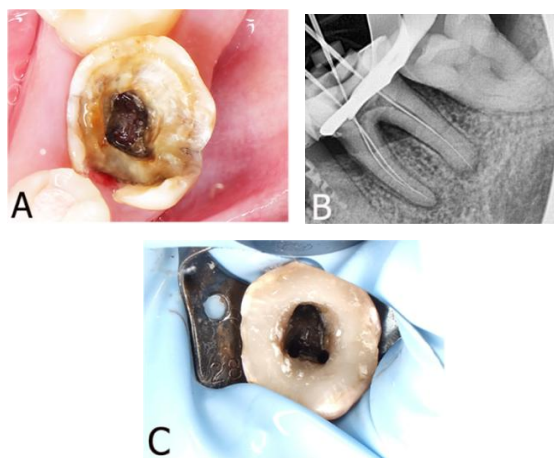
Removal of temporary restoration and infected tissue (A), radiographic confirmation of definitive working length (B), orifice of tooth 36 after preparation (C)
